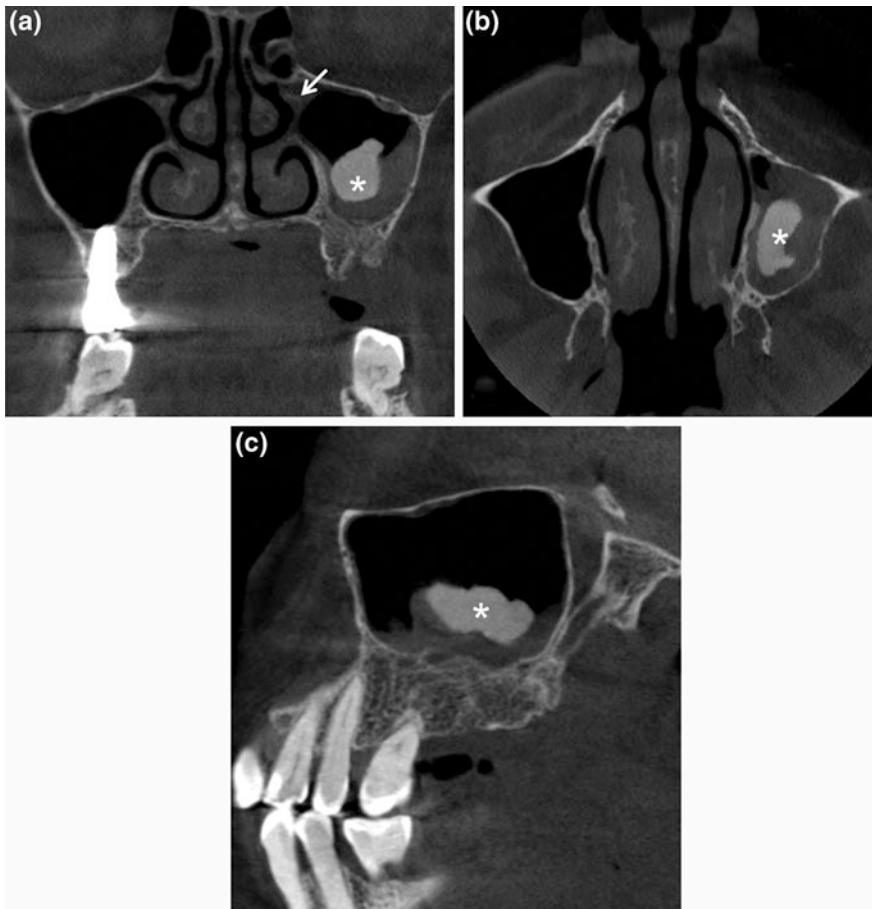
CBCT coronal (a) axial (b) and sagittal (c) sections showing irregular calcification tissue (*) at the center of the opacified left maxillary sinus. Note that the omolateral draining channels (ostium) is not preserved (*thin arrow*)
